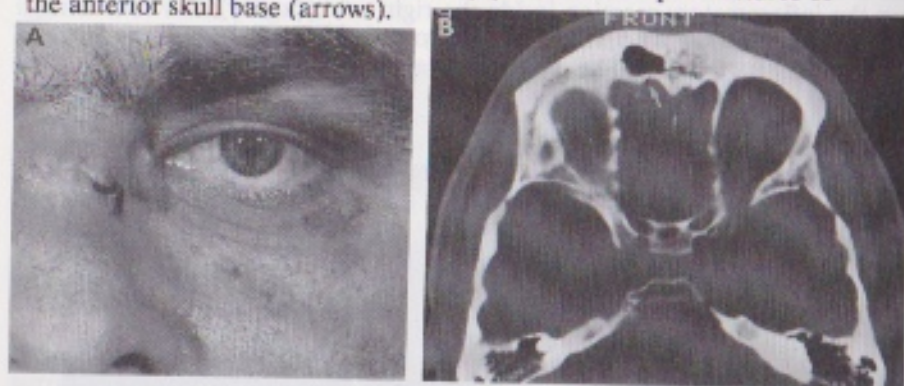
50 yrs. old patient with moderate external signs of facial trauma (A). After persistent CSF-rhinorrhea he underwent CT-examination ("high-resolution"-technique). The axial bone window scan revealed a fracture in the posterior wall of the left frontal sinus (B). Note the presence of an intracerebral air bubble (arrow).
